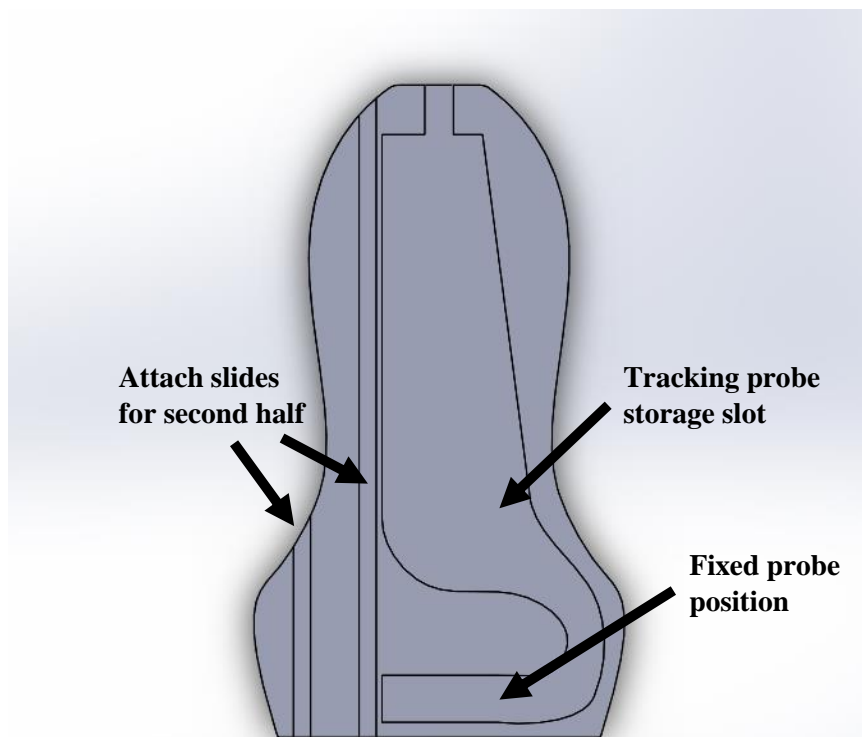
One half of the mock ultrasound probe showing how the tracking probe is stored.
